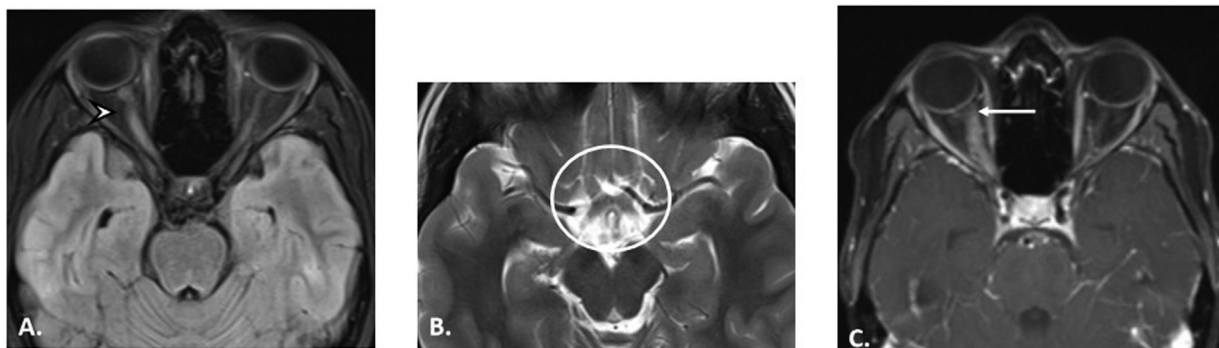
Myelin oligodendrocyte glycoprotein antibody-associated disease. (A) Axial fluid-attenuated inversion recovery image showing diffuse hyperintensity in right intra-orbital optic nerve with its thickening (arrowhead). (B) Axial T2-weighted imaging showing normal signal intensity in optic chiasma (circle). (C) Post-contrast axial image showing heterogeneous and perineural enhancement of involved segment of right optic nerve (arrow).
